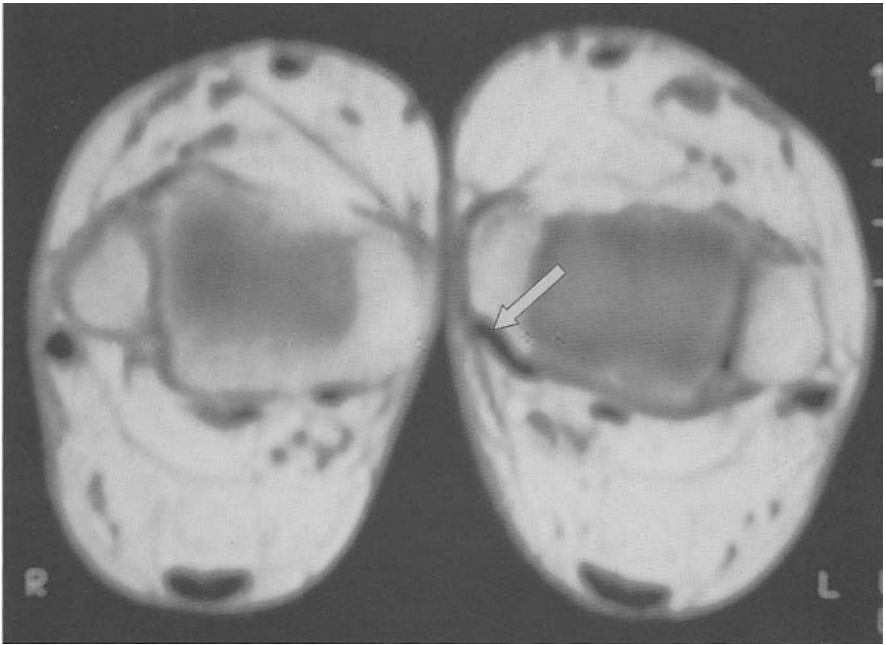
MRI: T1. Rupture of the right ptt (not visible). The left ptt is normal (arrow).
